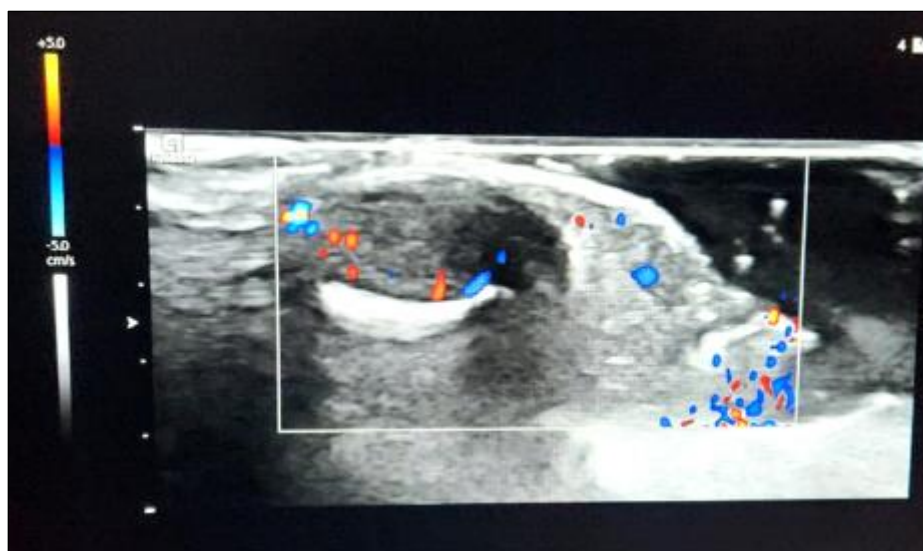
Longitudinal high-frequency color Doppler ultrasound of the distal phalanx: well-defined subungual nodule of the nail bed, isoechoic to the adjacent soft tissues, showing marked vascularity on color Doppler.
